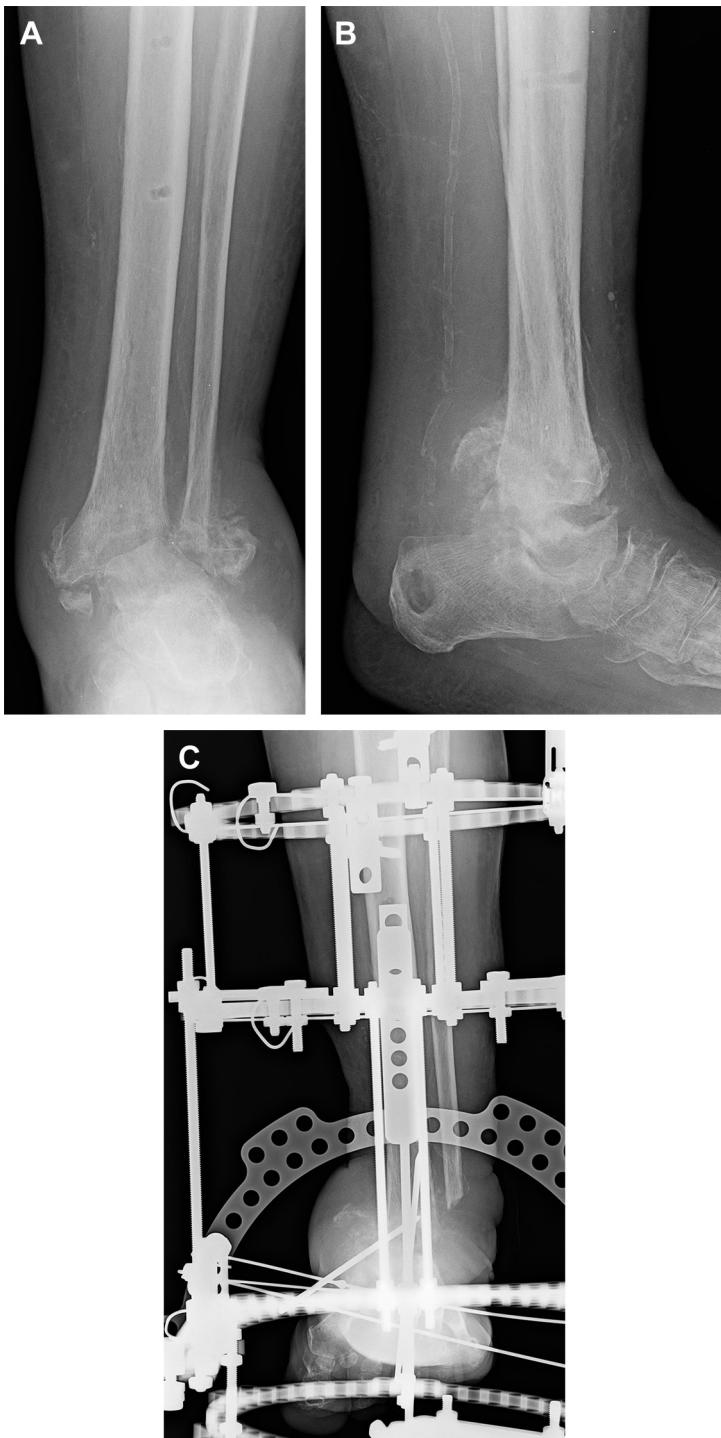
Anteroposterior (*A*) and lateral (*B*) radiographs of a closed tibial plafond fracture in a patient with diabetic neuropathy with uncontrolled diabetes with peripheral arterial disease and multiple medical comorbidities. Primary tibiotalocalcaneal arthrodesis was performed with a multiplane circular external fixator (*C, D*). Postoperative long-term anteroposterior (*E*) and lateral (*F*) radiographs demonstrate successful fusion.
